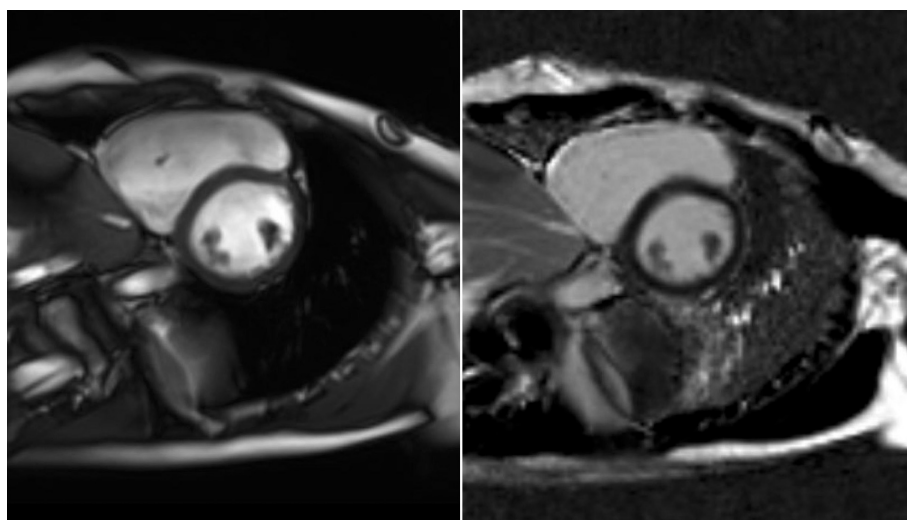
Results of magnetic resonance imaging of the heart with contrast.
